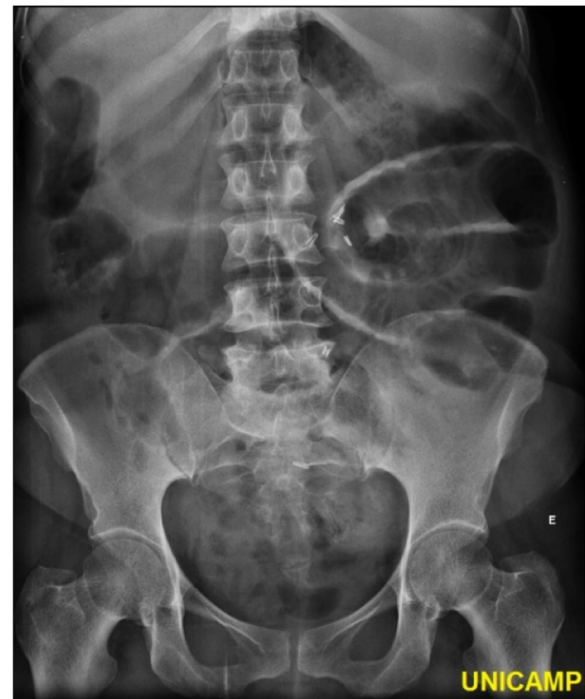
Simple abdominal radiograph showing dilated loops of the small intestine (jejunum) with visible convex valves, located mainly in the upper left quadrant.
